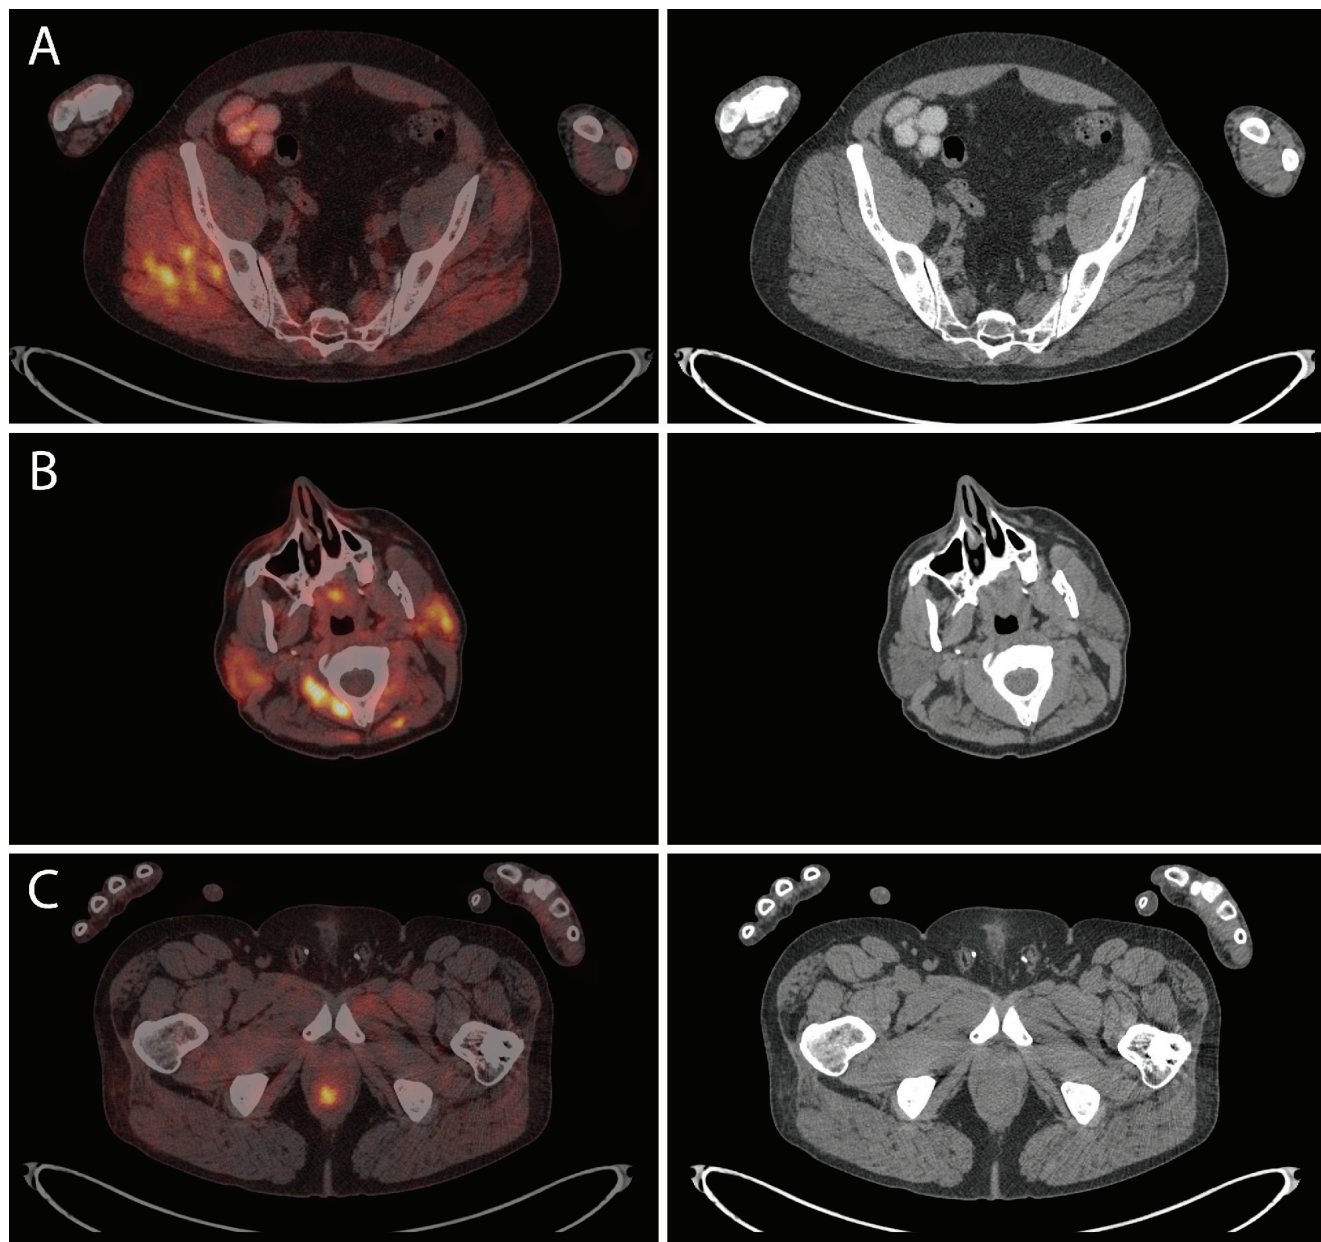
(A) Right gluteal muscles showed increased ^{18}F -FDG uptake with SUV_{max} 5.3, and (B) both parotid glands showed increased ^{18}F -FDG uptake with SUV_{max} 4.7 in the right and SUV_{max} 4.8 in the left, most likely due to alcohol/food consumption. (C) The rectal primary lesion had intense ^{18}F -FDG uptake with SUV_{max} 5.2 and there was no evidence of distant metastases. The ^{18}F -FDG physiologic uptake artifacts from physical activity and movements of the right hand, arm, shoulder and gluteus maximus (as well as drinking and eating), with normal corresponding CT findings, did not interfere with cancer staging. It is important that a patient is relaxed at time of ^{18}F -FDG injection and has avoided vigorous exercise in the hours leading up to the PET/CT. Most authors recommend avoiding physical exercise 24 hours before ^{18}F -FDG administration (1,2,3,4), although vigorous exercise up to 4 days before imaging has been reported to cause muscle ^{18}F -FDG uptake artifacts (5). Diffusely increased ^{18}F -FDG uptake in muscles, as a PET/CT artifact, has been described in the following situations: insulin administration (6), voluntary physical activity such as chewing gum, exercise or sexual activity (4,5,7), involuntary physical activity such as labored breathing or muscle spasms (8), post surgical changes (9,10), post radiation inflammation (11), dermatomyositis (12), infection (10,13,14), or post injection (15). Unilateral intense muscle ^{18}F -FDG uptake is rare and has been described in a few cases such as hemiparesis from stroke (16), in patients with multiple sclerosis (17), due to tracer injections (15) or more commonly in certain head and neck muscles (18). Non-compliance with patient instructions during the uptake phase of ^{18}F -FDG can cause significant artifacts and recent examples in the literature include smartphone use (19), reading a small book and even tapping the foot (20).
